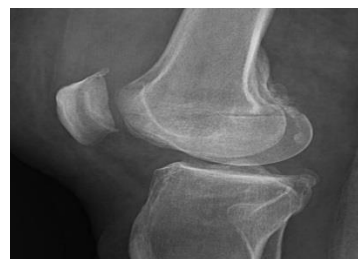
Lateral x-ray of the knee joint showing distal femoral fracture
